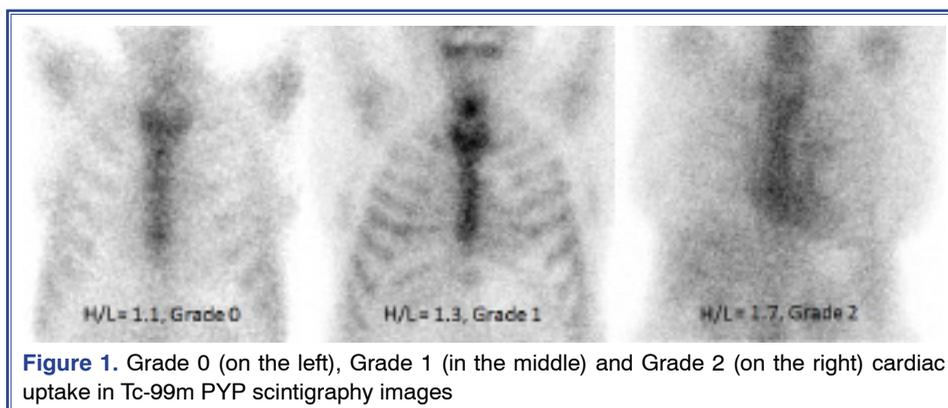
Grade 0 (on the left), Grade 1 (in the middle) and Grade 2 (on the right) cardiac uptake in Tc-99m PYP scintigraphy images
